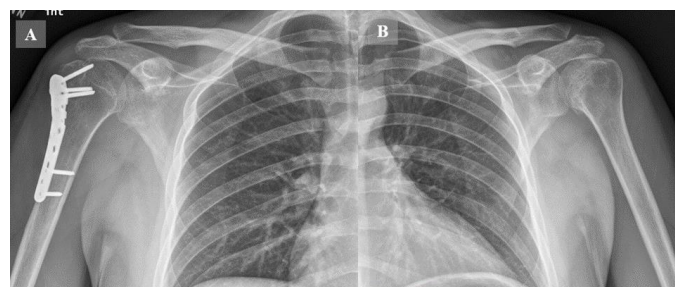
X-ray imaging at 3 months post-surgery showing appropriate fixation and reduction of the greater tuberosity on the right shoulder (A), and the lesser tuberosity fracture in the left shoulder (B)
